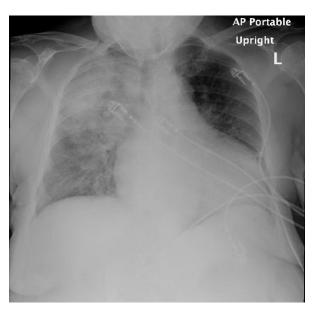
Chest radiograph showing right upper lobe opacity with bilateral interstitial infiltrates.
